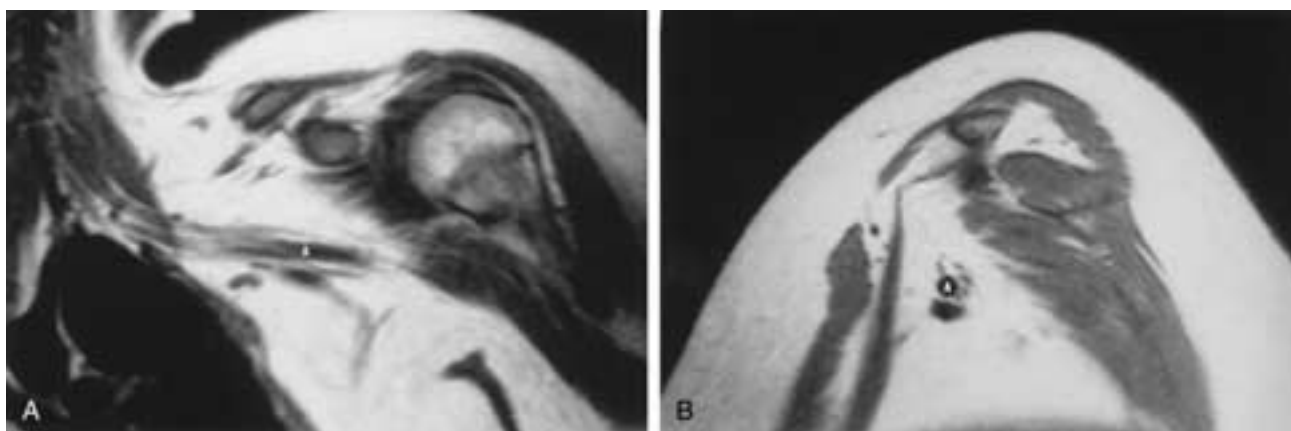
Brachial plexus, supraclavicular and axillary regions. Coronal MR image (A) shows the components of the brachial plexus in the supraclavicular region and axilla. The nerves surround the axillary artery (A). Sagittal MR image (B) obtained through the axilla demonstrates the peripheral nerves formed by the brachial plexus surrounding the axillary artery (A).
